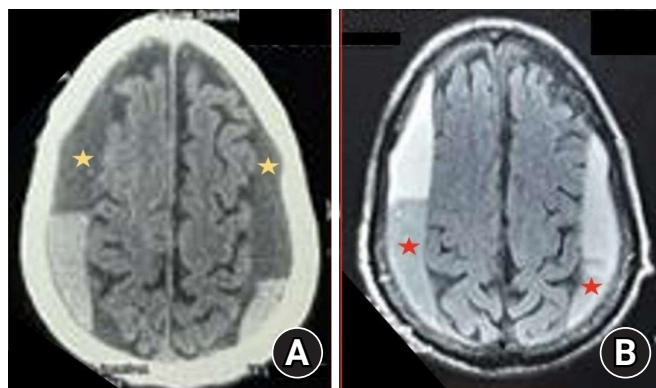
Non-contrast CT scan head showing a bilateral collection of the layered type of subdural hematoma. (A) The yellow stars suggest chronic subdural hematoma. (B) The red stars in the FLAIR sequence of the MRI brain suggest the subacute nature of subdural hematoma which indicates a layered type of chronic subdural hematoma.
